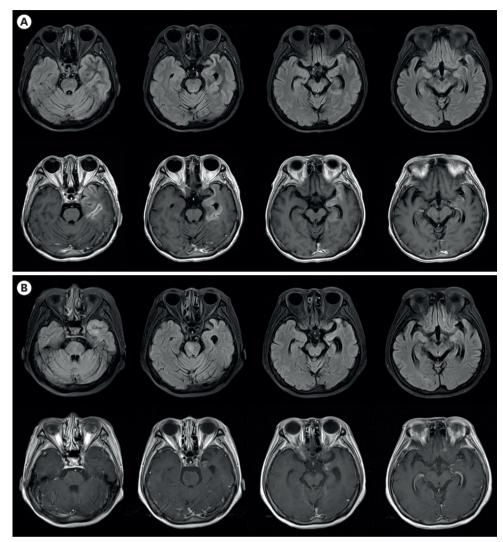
Brain magnetic resonance images of the patient. (A) Left temporal high signal intensities (upper, fluid attenuated inversion recovery) and gyral enhancements (lower, T1-weighted contrast enhancement) at initial admission. (B) Disappearance of the left temporal lesion after one year.
